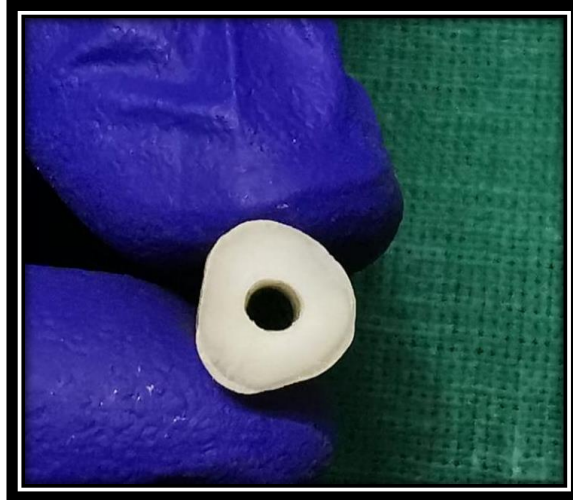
9 - OPEN APEX VERIFIED WITH RADIOGRAPH
